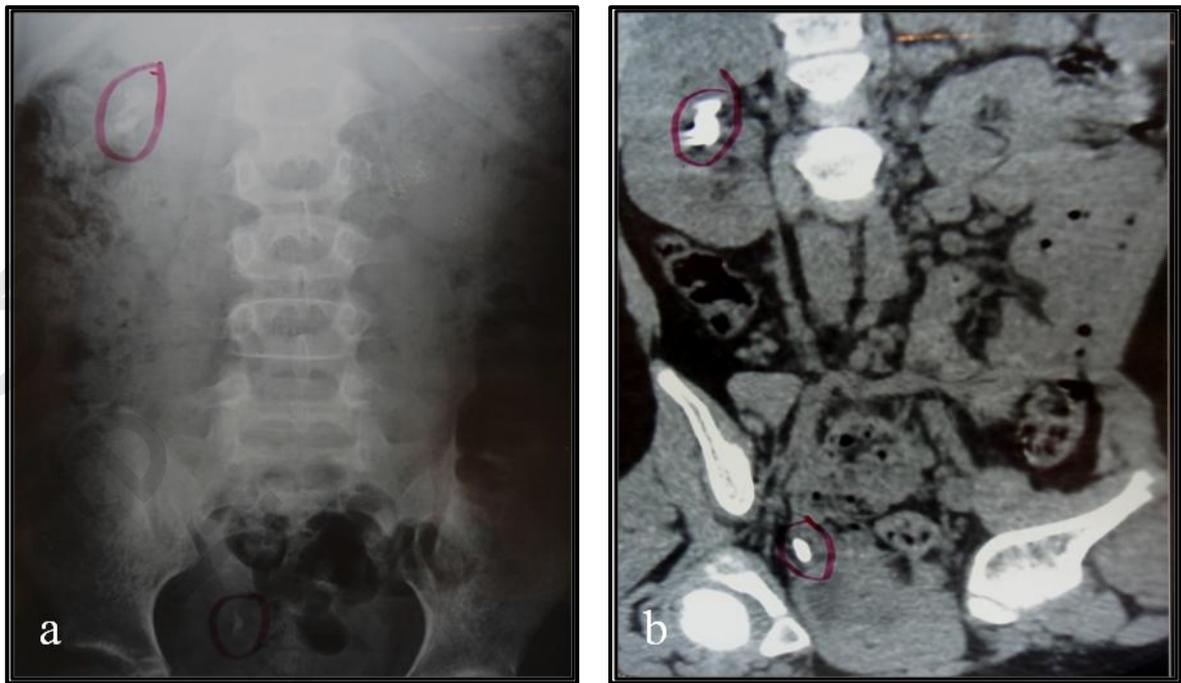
Showing (a) plain KUB and (b) coronal cut of multislice CT abdomen and pelvis in 5 years old female child having right middle calyceal renal stone and right lower third ureteric stone.
